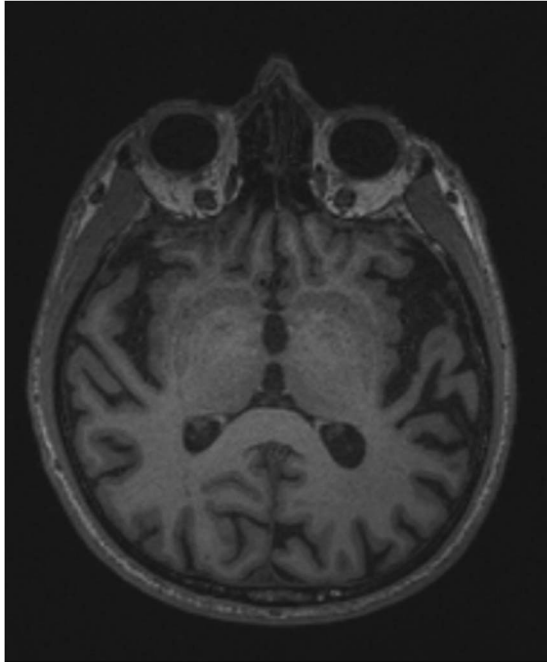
Axial MRI of Case 4 showing moderate left-lateralized temporal cortical atrophy, consistent with the pattern of atrophy typically seen in the logopenic PPA syndrome. Image right is patient left.
